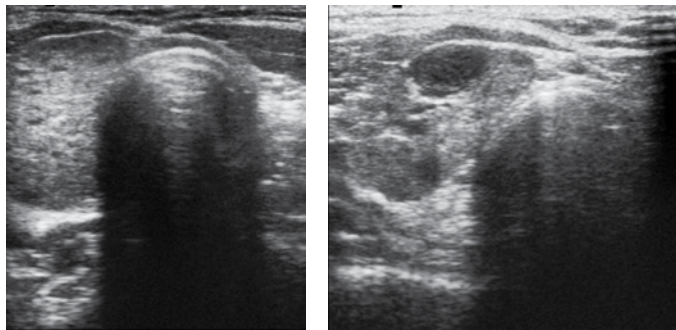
A and B. Ultrasonographic image of hemiagenetic thyroid gland
